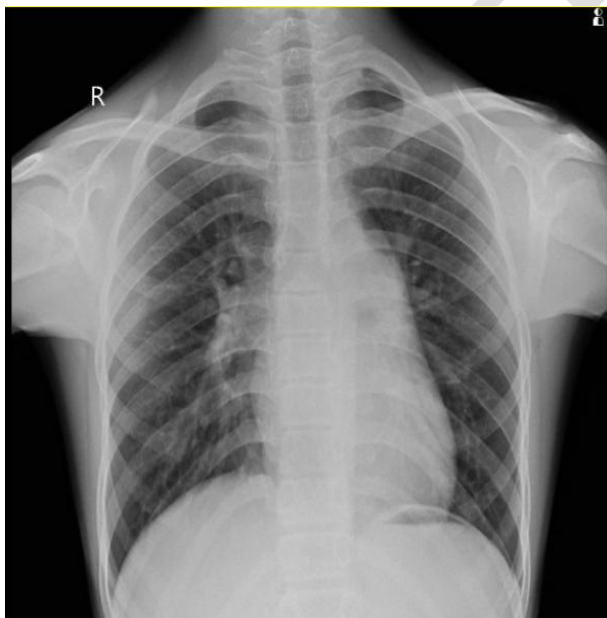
Pre-operative xray showing elongated heart and prominence of vascular zone in right lung
